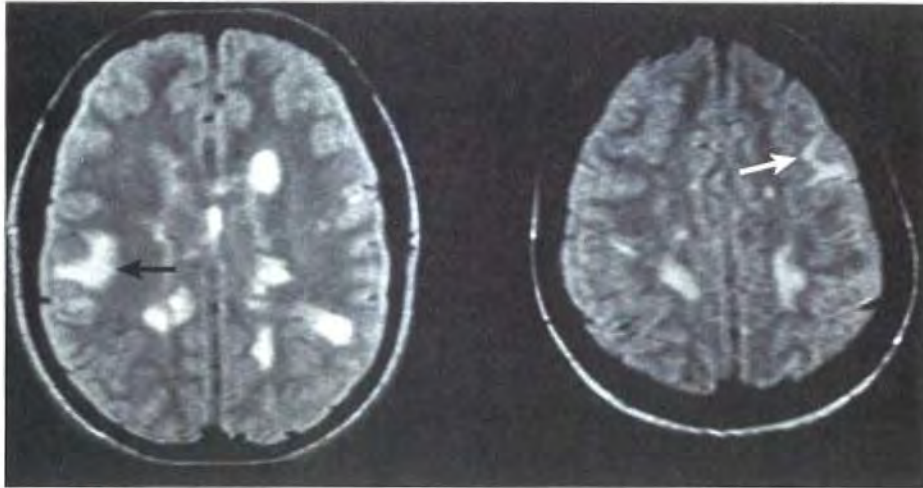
Multiple sclerosis. T₂-weighted MRI scans show juxtacortical lesions (arrowed).
